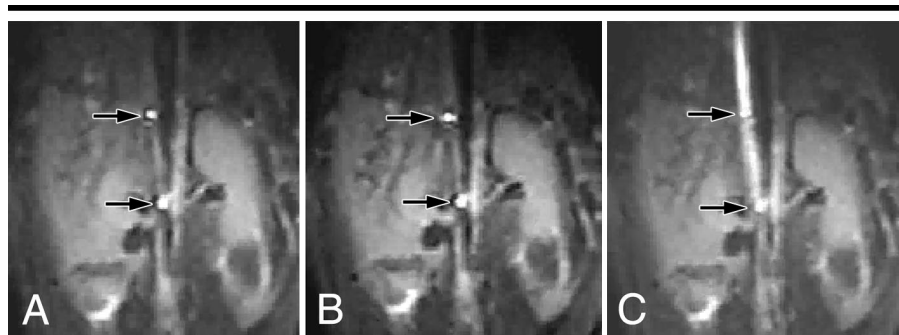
Transverse interactive steady-state free precession (2.9/1.6; flip angle, 45°; section thickness, 8 mm; acquisition frame rate, 8 per second; field of view, 280 mm; matrix, 128 × 128) MR images of the inferior vena cava and SDS with paired decoupled RCs (arrows) show that SI of the RCs remained comparable in three different conditions: with the working lumen of the SDS filled with saline solution (A); with a 0.035-inch polyester guidewire advanced through the saline solution-filled lumen (B); and with a 0.035-inch nitinol guidewire inserted in the saline solution-filled lumen (C). Because the nitinol guidewire acts as an antenna, SI in the SDS is increased on C.
